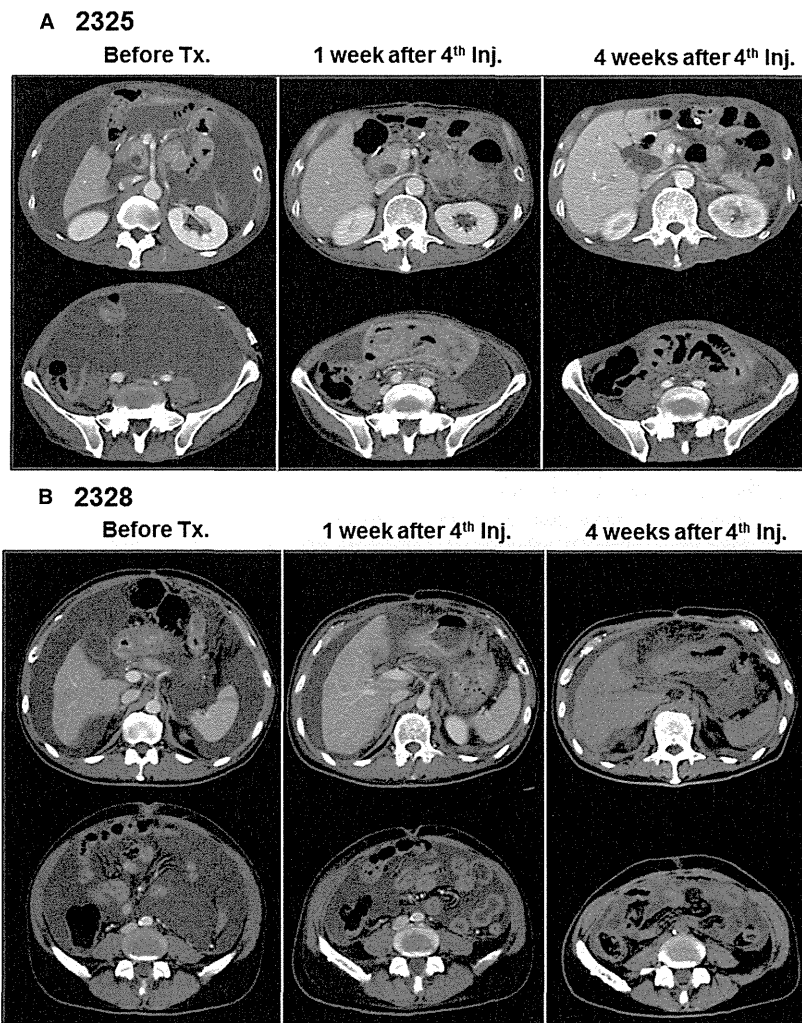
Computed tomography findings in patients 2325 (A) and 2328 (B). Retention of a large amount of ascites was observed before treatment (left panels). The amount of ascites was reduced 1 week (middle panels) and 4 weeks (right panels) after four courses of V γ 9V δ 2 T-cell injections.
